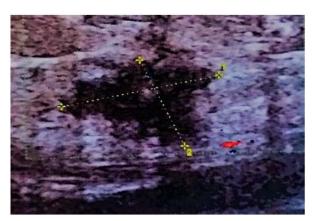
Ultrasound image showing the endometriosis nodule
